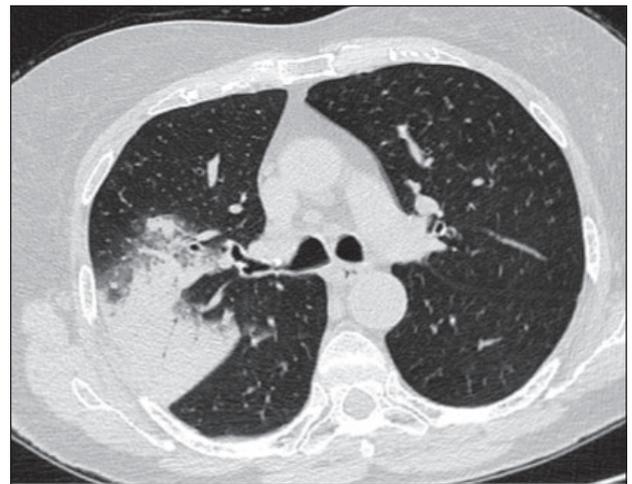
Chest computed tomography confirmed an upper lobar consolidation and a small pleural effusion.
